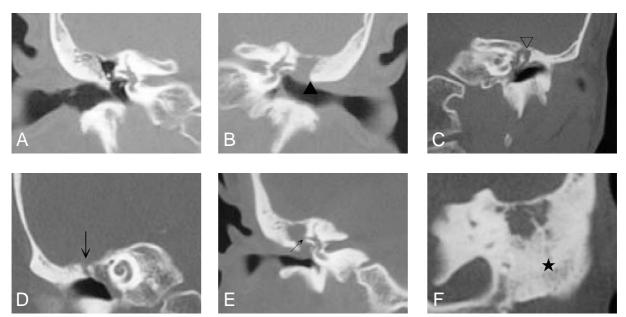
The temporal bone patterns in patients with cholesteatoma by high resolution temporal bone computed tomography. A: Normal middle ear and mastoid cavity, the sharp-angled scutum, intact tegmen mastoid-tympanicum and otic capsule. B: The blunted scutum ( $\blacktriangle$ ). C: Erosion of ossicular chain ( $\bigtriangledown$ ). D: Erosion of tegmen mastoid-tympanicum ( $\downarrow$ ). E: Erosion of otic capsule (the lateral semicircular canal) ( $\nearrow$ ). F: Marked sclerotic change of mastoid ( $\bigstar$ ).
